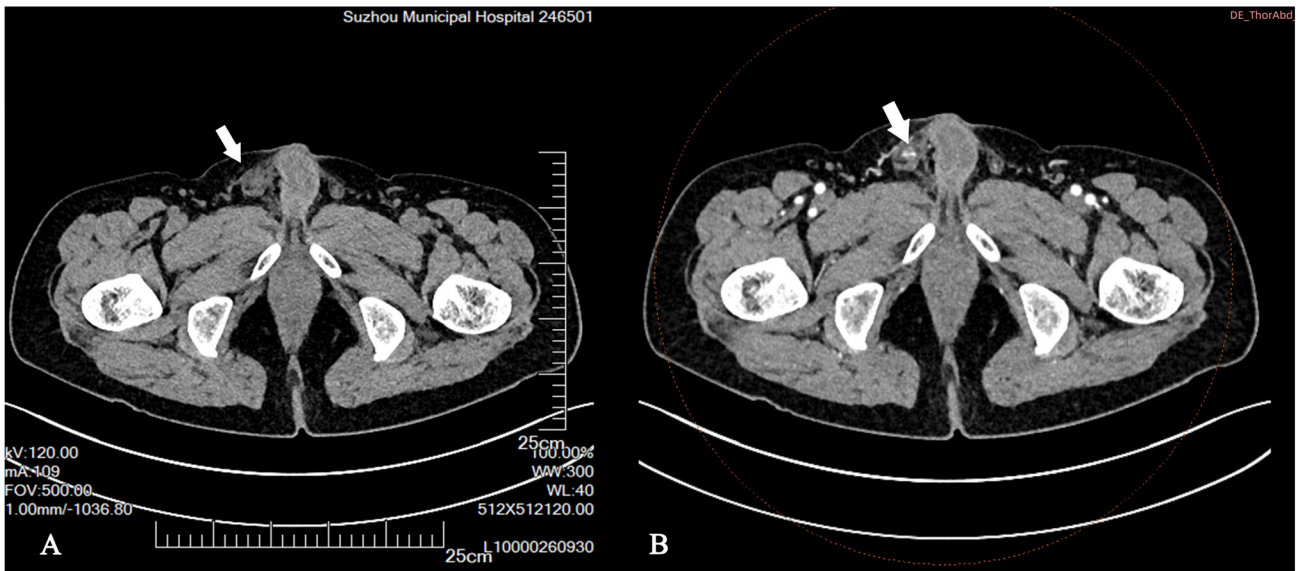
(A) Non-contrast and (B) arterial-phase contrast-enhanced computed tomography demonstrating right testicular enlargement with heterogeneous enhancement and cystic components, accompanied by an enlarged lymph node adjacent to the right external iliac artery.
